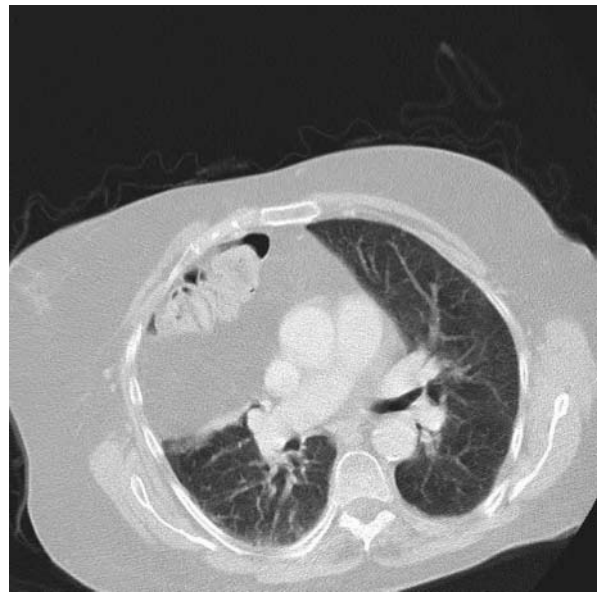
CT demonstrating herniation of a large bowel segment with associated omentum into the thorax.
